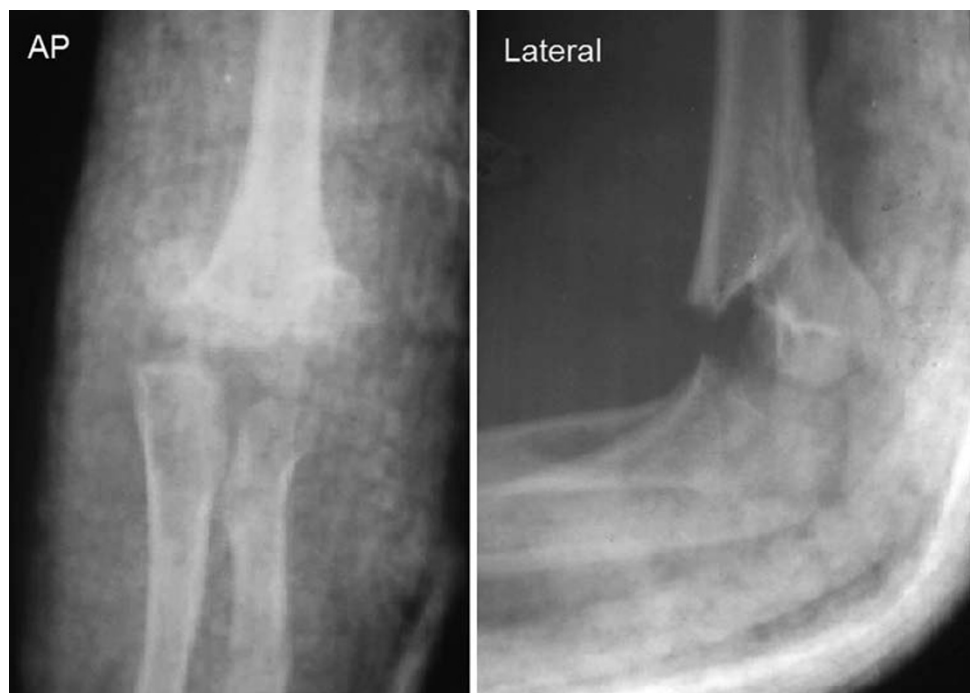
The 6-year-old boy was referred to our hospital 10 days after the initial injury because of failure of close reduction. The anteroposterior and lateral radiographs showed severe displacement
